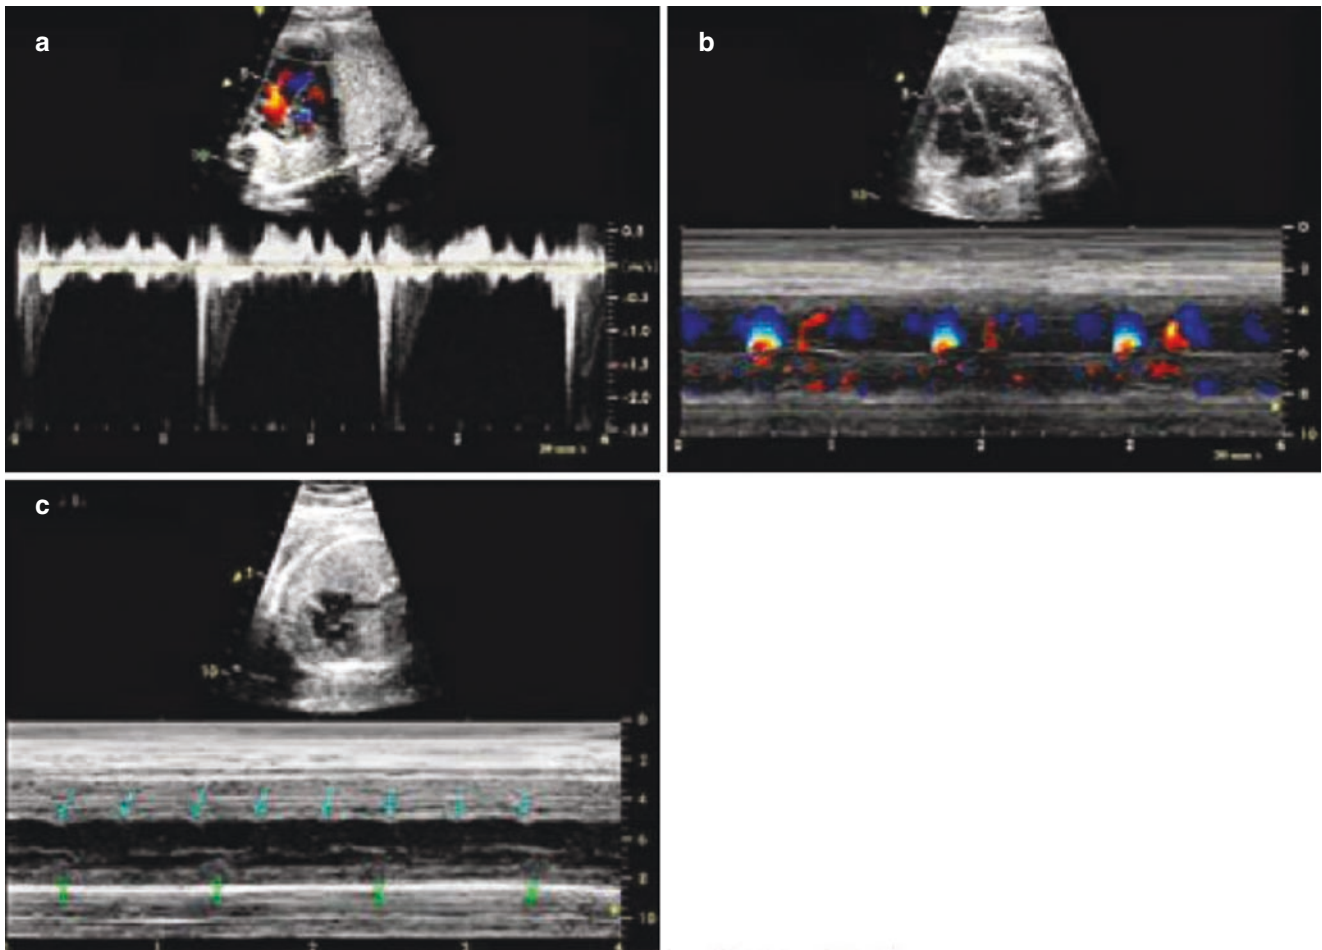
Bradyarrhythmia. (a) Spectral Doppler ultrasound shows that the atrial and ventricular dissociation without dependence. (b) M-mode color ultrasound shows that the movement curves dissociation
